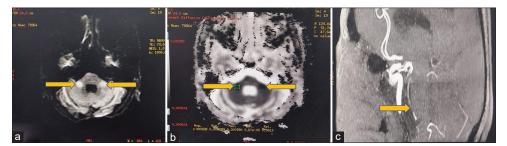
Magnetic resonance images brain. (a) Diffusion-weighted image–Arrow head showing hyperintensity in the bilateral cerebral peduncle, (b) Arrowhead showing apparent diffusion coefficient–Hyper-intensity in the bilateral cerebral peduncle, (c) Time of flight-filling defect in basilar artery
